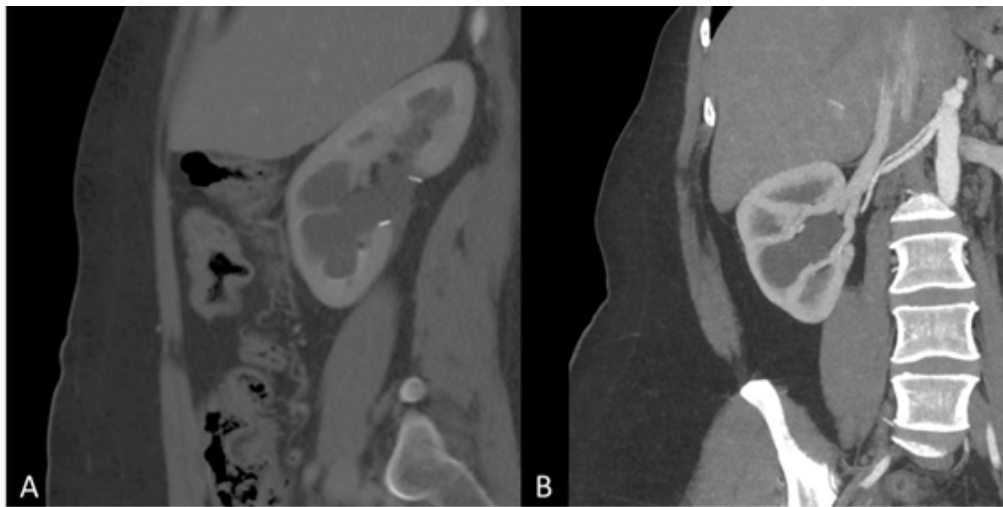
Surgical clips are noted along the renal pelvis (red arrows in A) which is higher than the ureter stricture. On coronal CT (B), anatomical variant of renal arteries is present with double arteries supplying the right kidney.
